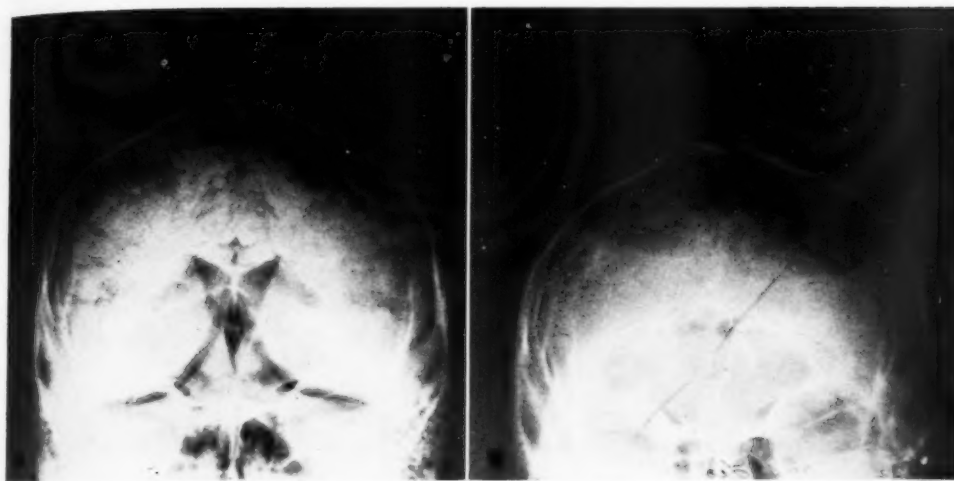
A. Immediate pneumoencephalogram, showing large subdural gas accumulations under the tentorium; none over the convexity of the cerebral hemispheres. B. Twenty-four-hour roentgenogram. There now are collections of subdural gas over the convexity, while that under the tentorium has disappeared. This may represent only a shift of the gas originally subtentorial, since the amount of gas seems about equal and the gas probably was introduced into the subdural space at the time of injection.
